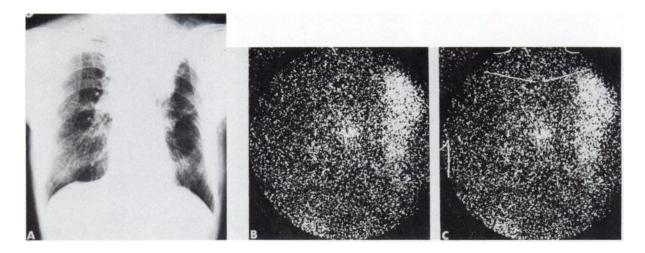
Patient with planocellular cancer of left lung. (A) Chest x-ray; (B) anterior scintigram of thorax showing radioactivity in tumor and mediastinum (at operation malignant tissue was found
